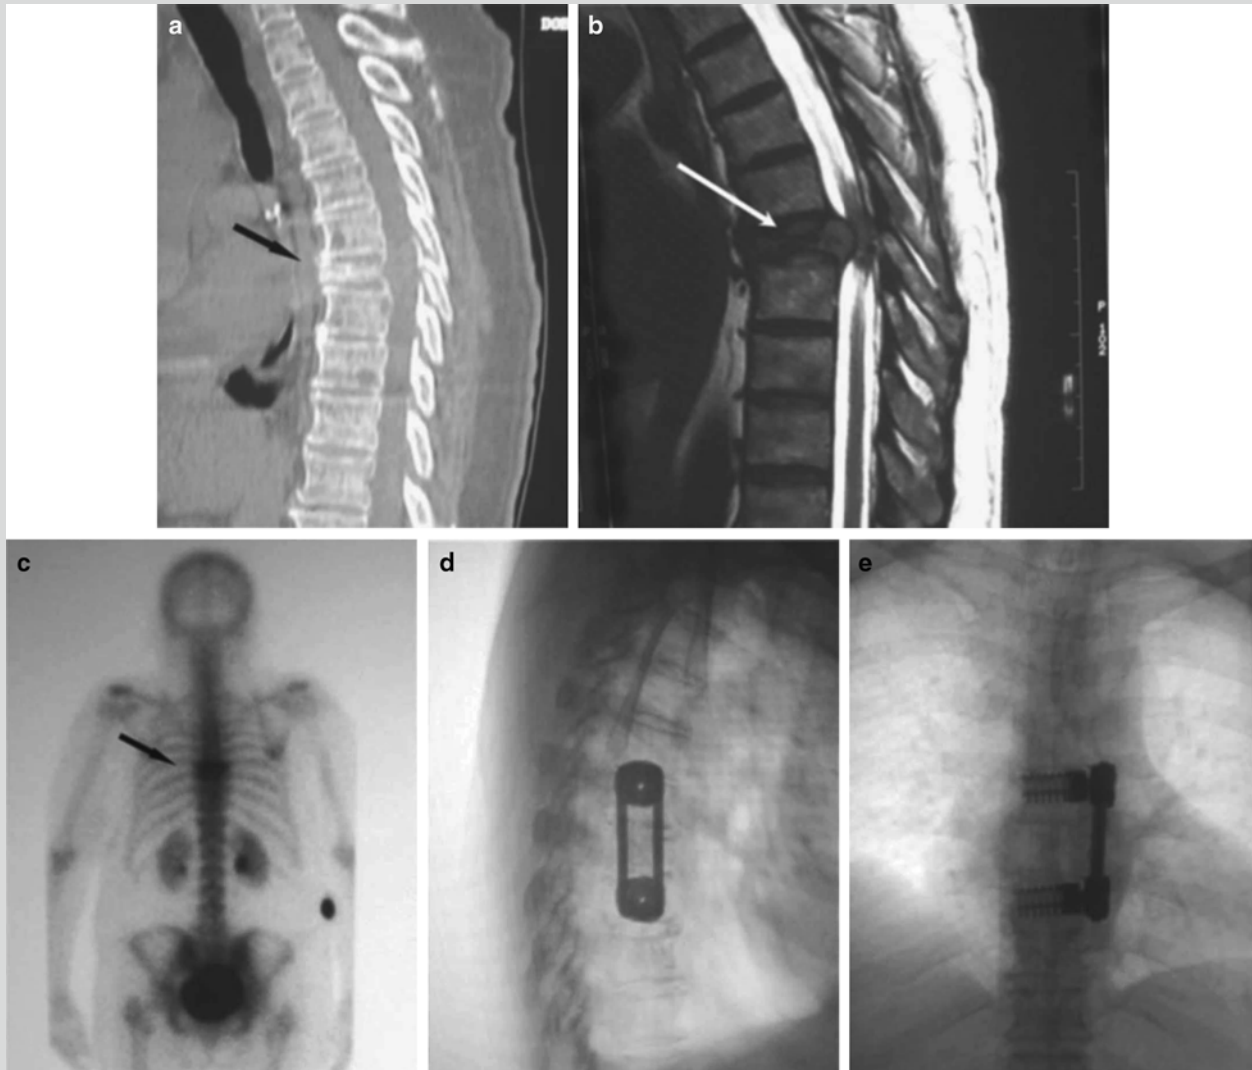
(a–e) Plain CT scan showing a pathologic fracture at T7 (a). MRI thoracic spine T2WI revealed the cord compression (b), and SPECT studies showed no evidence of other lesions (c). The patient underwent an urgent T7 corpectomy via a transthoracic approach. The vertebral body was replaced by a PEEK vertebrectomy spacer packed with rib autograft and supplemental plating was utilized. Postoperative plain X-ray lateral (d) and AP view (e) showing the instrumentation
